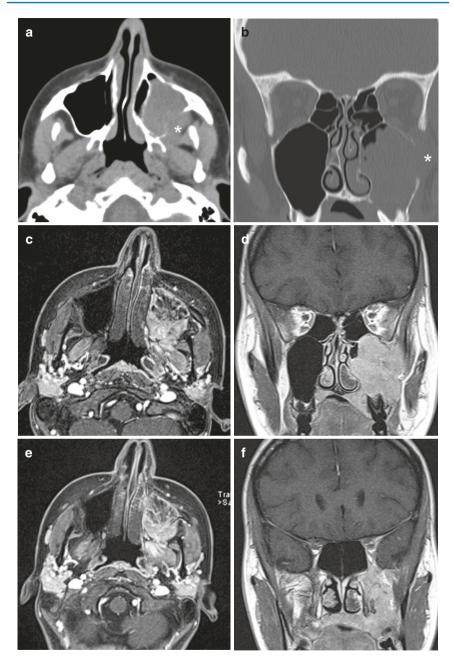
Serendipitous finding of an otherwise asymptomatic left maxillary lesion in a 24-yearold girl at plain CT on axial (a) and coronal (b) planes; erosion of the posterior wall of the sinus with possible extension (asterisk) into the surrounding spaces is evident. MRI on axial (c, e) and coronal (d, f) planes better depicts the presence of a malignant tumor (later revealed to be AdCC), infiltrating the posterior wall of the maxillary sinus and massively involving the pterygoid root, pterygopalatine fossa, and masticatory space
